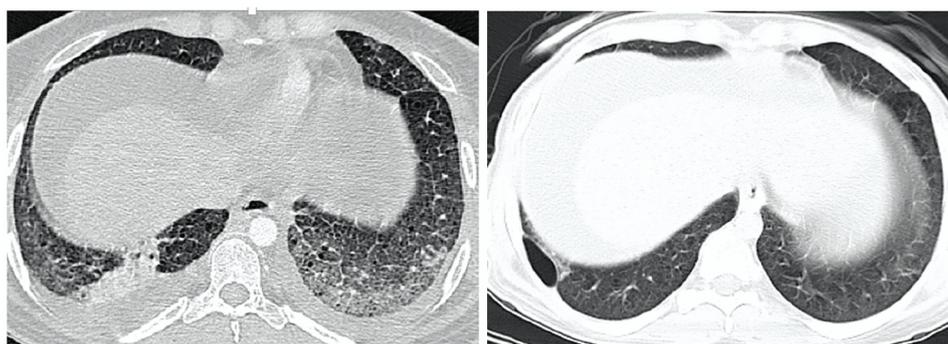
The Left figure shows HRCT (high-resolution CT scan) at the lung base level. The same findings are seen here. The presence of pulmonary edema is evident. Patchy consolidation on right is suggestive of atelectasis. The right figure shows the follow-up, several months following treatment. No pleural effusion, pulmonary edema, or atelectasis are present. A tiny loculated pneumothorax on right implies previous complications and adhesions.
